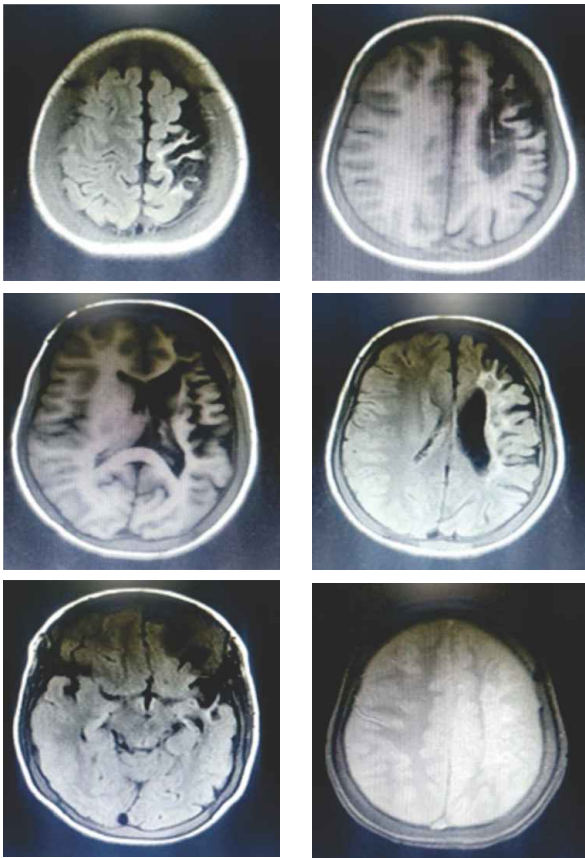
Magnetic Resonance imaging scan revealing ipsilateral displacement of left falx cerebri, cerebral atrophy and elevation of petrous ridge with hyperpneumatization of left frontal sinus
